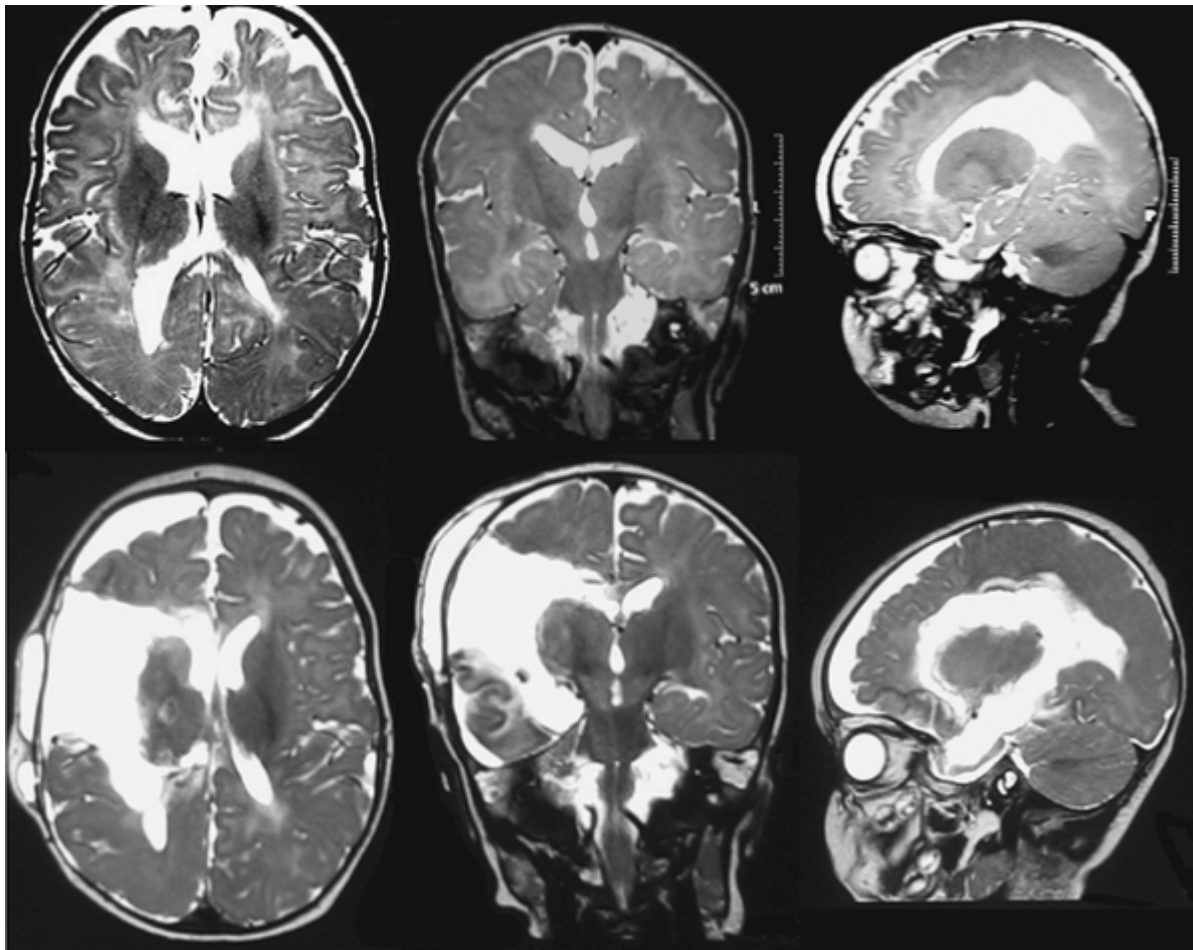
Right-sided hemimegalencephaly in a 7-month-old male. Preoperative T2-weighted magnetic resonance images (top) demonstrate an enlarged right hemisphere with impaired sulcation, especially posteriorly. Corresponding axial, coronal, and sagittal postoperative images (bottom) demonstrate functional hemispheric disconnection. This case was done with a perisylvian window technique.
